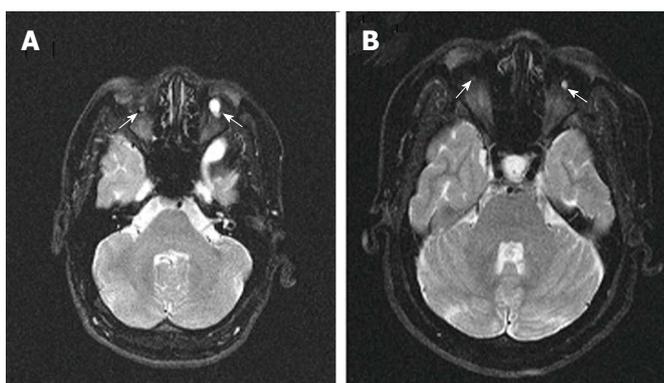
Axial fat-suppressed T2-weighted magnetic resonance imaging. A: Axial fat-suppressed T2-weighted magnetic resonance imaging (MRI) of the male patient showed bilateral cystic structures that are synonymous with rudimentary eyeballs (white arrows); B: Axial fat-suppressed T2-weighted MRI of the female patient showed bilateral cystic structures that are synonymous with rudimentary eyeballs (white arrows).
